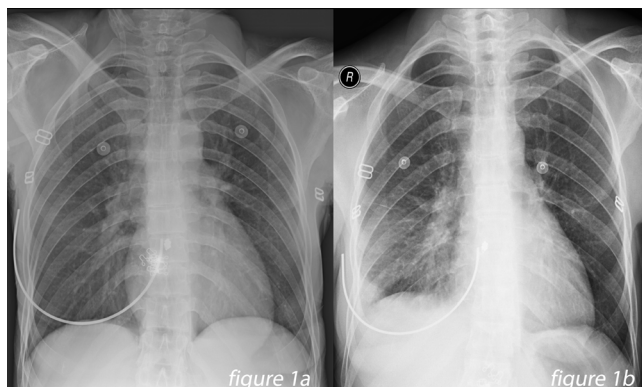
The posteroanterior initial chest X-ray with normal findings; b, the chest roentgenogram after 3 days of the same patient showing blunted right sinus.
